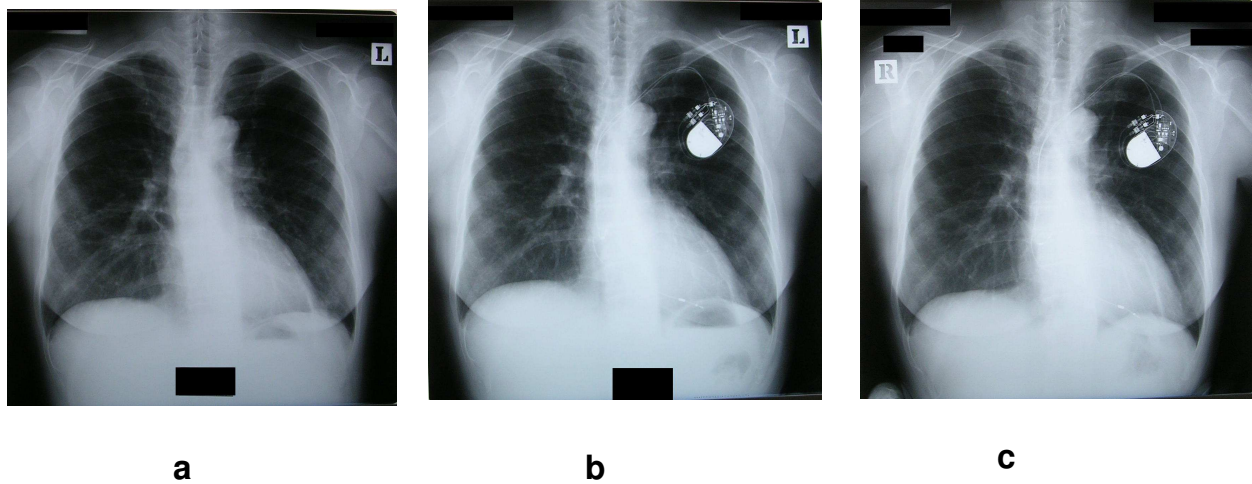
Longitudinal course of plain chest radiograph 62-year-old female, nonsmoker, BHL, lung, ACE 29.0, heart with complete AV block, a: when the introduction of corticosteroid and methotrexate therapy was introduced, b: after 2 years of treatment c: after 5 years of treatment
